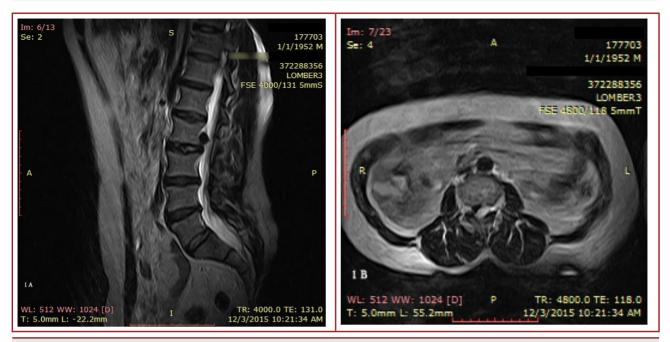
Sagittal (A) and axial (B) T2W MRI's shows intracanalicular low signal 1x1x1,5 cm. mass lesion compressing techal sac on lower right corner of the L2 vertebra.
